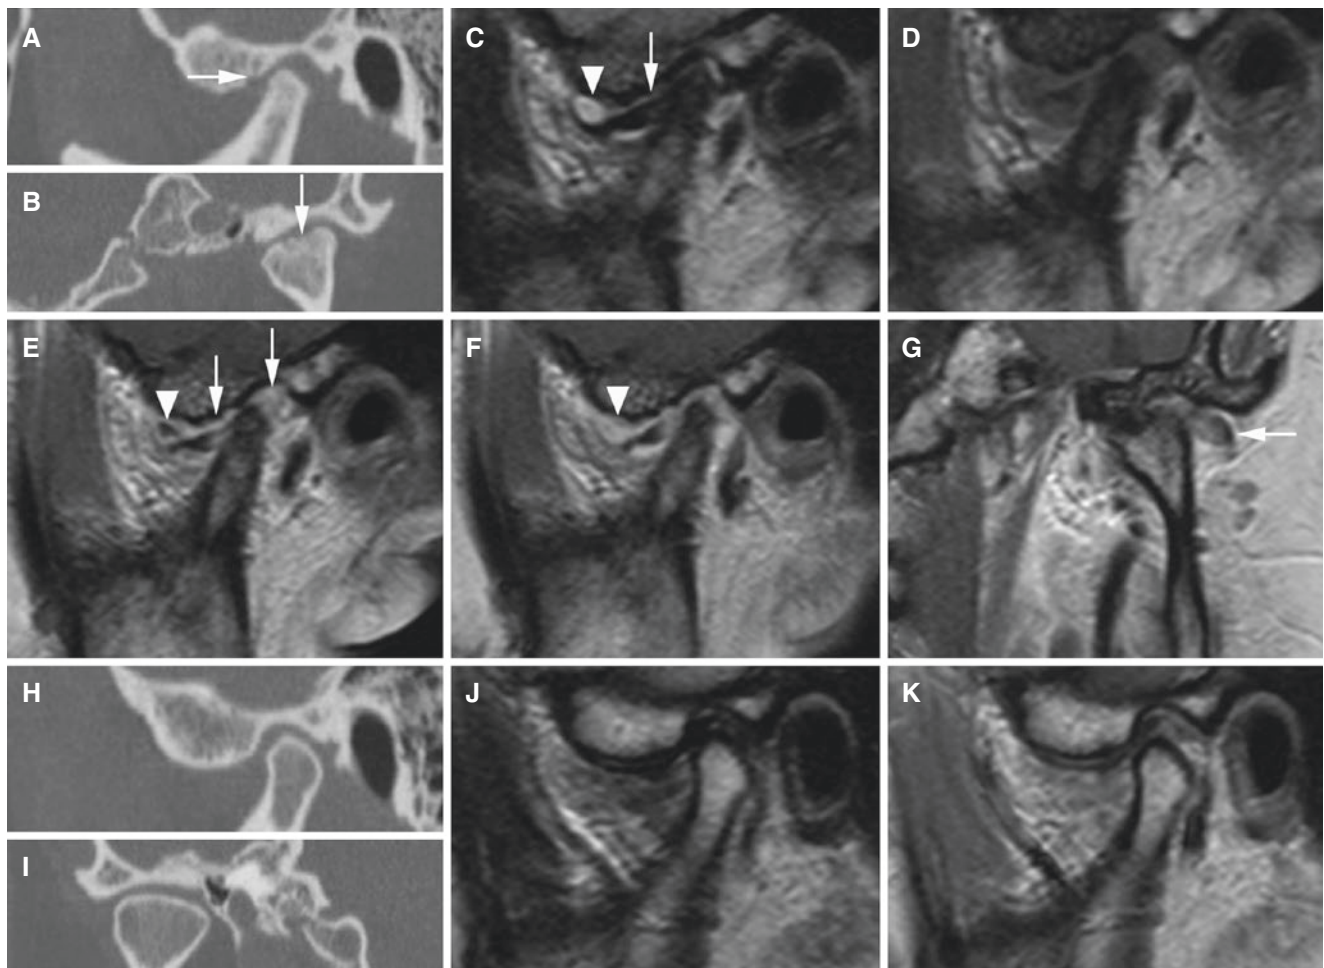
Osteoarthritis with contrast enhancement (synovitis), surgically treated; 38-year-old female. (A) Oblique sagittal and (B) oblique coronal CT images show somewhat sclerotic condyle and surface irregularities of eminence and condyle (*arrow*). (C) Oblique sagittal T2-weighted MRI shows joint effusion particularly in anterior recess of the upper compartment (*arrowhead*) and anteriorly displaced disc (*arrow*). (D) Oblique sagittal T1-weighted pre-Gd and (E) oblique sagittal T1-weighted post-Gd MRI show contrast enhancement in joint
